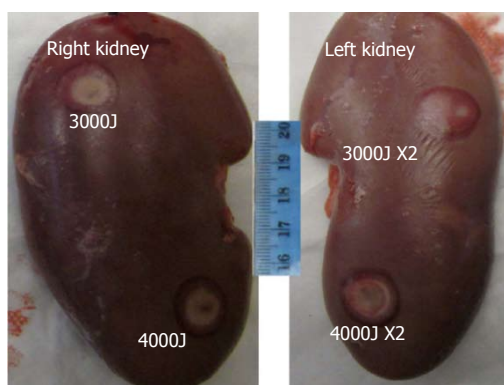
Macroscopic dorsal lesions in the right (single sonication) and left (double sonication) kidney are shown after high intensity focused ultrasound. Note the doughnut-shape hemorrhage (dark red) is surrounding coagulation necrosis (pale). Double sonication at 4400J produced larger lesions compared with the others.
